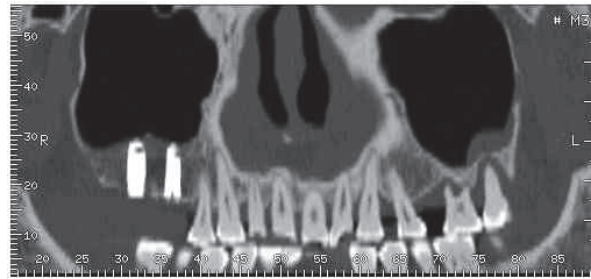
CT scan shows newly formed bone in the sinus after 6 months healing.
